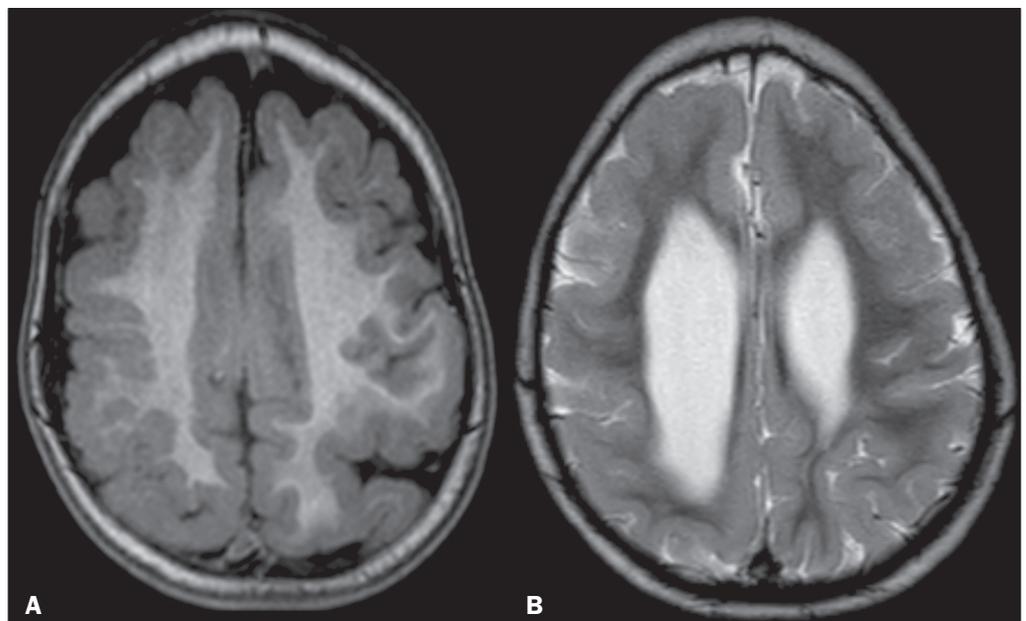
Malformations of cortical development on MRI in a 19-month-old patient. Axial T1-weighted and T2-weighted sequences (A and B, respectively) showing global cerebral volume loss and patchy white matter signal. In the cerebral cortex, note the heterogeneous admixed areas of polymicrogyria and pachygyria.
